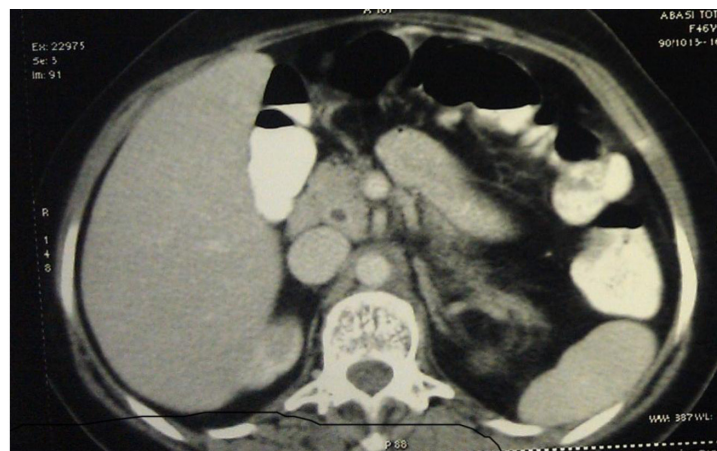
Spiral computed tomographic scanning shows more than 30% decrease in primary, celiac and paraaortic masses.
